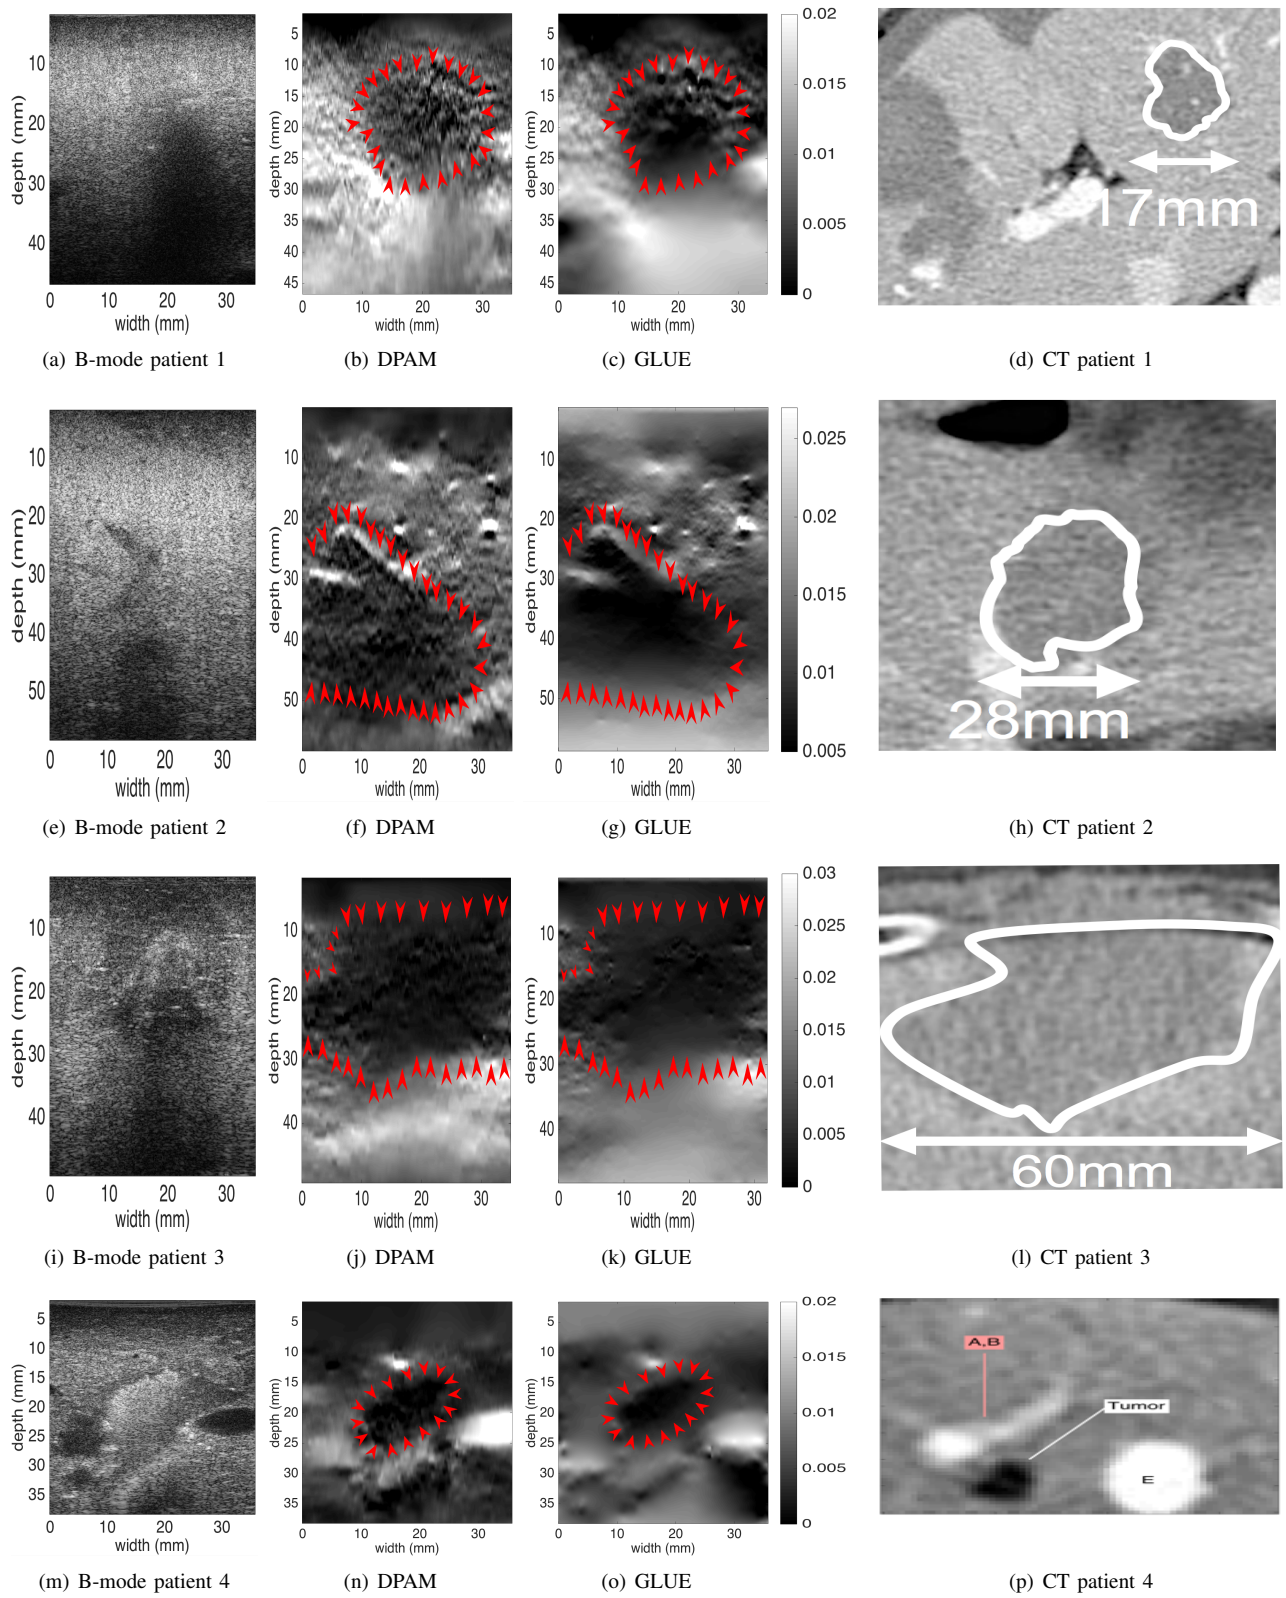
In-vivo* images of the ablation lesion acquired after ablation of liver tumours. Each row corresponds to one patient. The first column shows ultrasound images, and the second and third columns respectively show the results of DPAM and GLUE. The ablation lesion is marked with red arrows, and is clearly visible in strain images. CT images with the delineated ablation lesions are shown in the right column.
